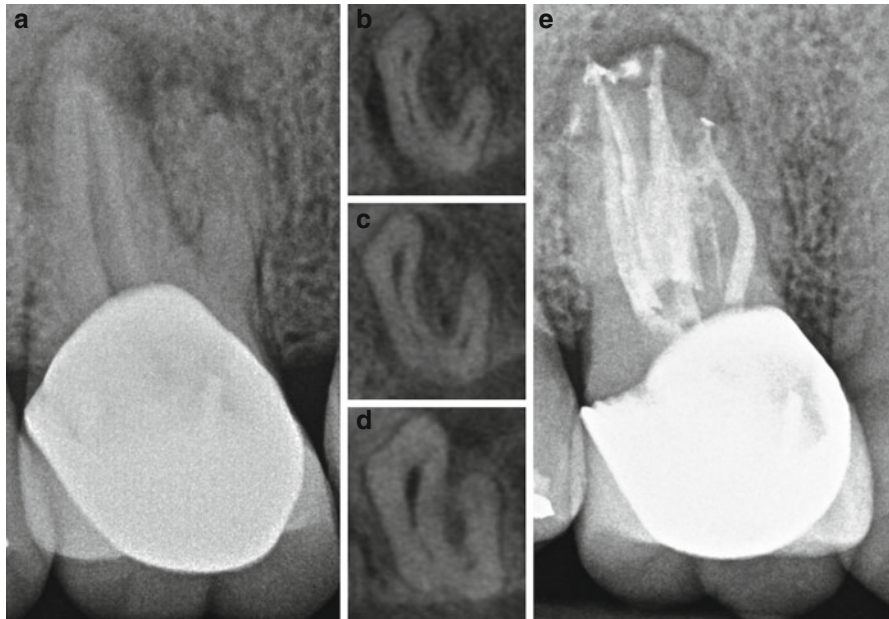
Preoperative periapical radiograph of a maxillary right first molar (a) with corresponding axial CBCT slices captured from the apical third (b), mid-root (c), and coronal third (d) demonstrating a C-shaped external root form and confluent root canal configuration. The post-endodontic radiograph demonstrates proper management of the C-shaped internal root canal anatomy (e) (Case courtesy of Dr. Hong Chon, Specialized Endodontic Solutions, Bloomingdale, IL)
